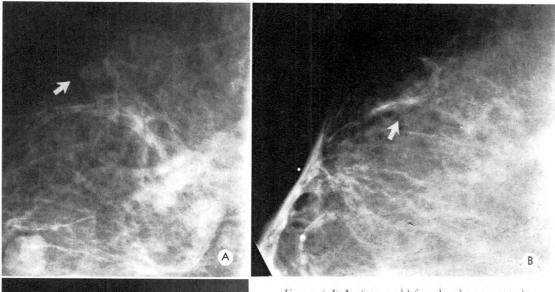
(A) A 56 year old female who presented with a moderate sized, sharply circumscribed and lobulated, soft tissue shadow at the site of a clinical mass (lower left corner). The roentgen impression was a fibroadenoma. However, a small soft tissue shadow with numerous small calcific particles also suggested a malignancy which was not palpable (arrow). Localization was not done. Surgery revealed the palpable mass to be a fibroadenoma. (B) A study 2 months later showed the suspected carcinoma, which was still not palpable, and an increased number of calcific particles (arrow). Surgery without specific localization was performed. The tissue was negative for cancer. (C) A roentgenogram 2 months later showed again the suspected carcinoma (arrow). At this time a specific area localization was made and a small nonpalpable carcinoma was removed at surgery.
